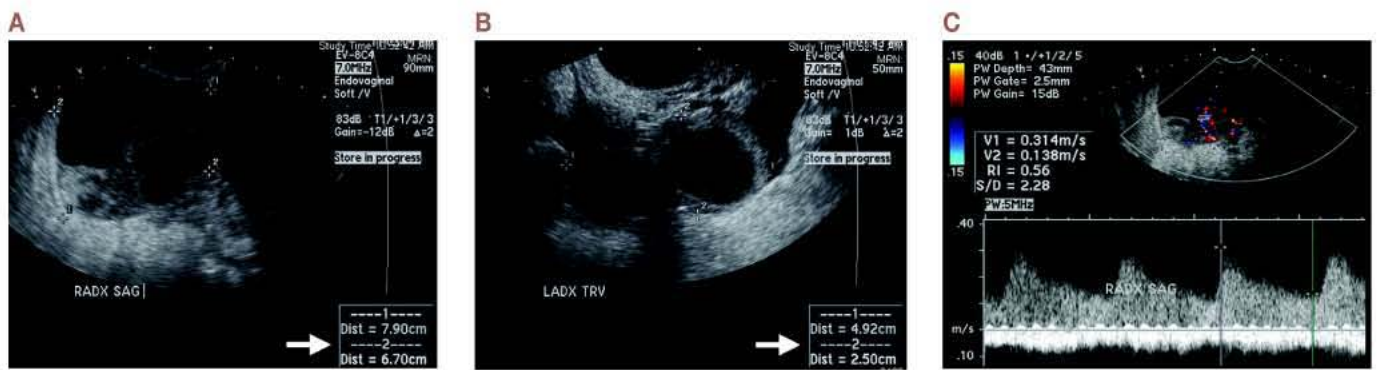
US images show enlarged, multicystic right (A) and left (B) ovaries consistent with OHSS. The right ovary is asymmetrically enlarged (arrow), the only clue to ovarian torsion in this case. (C) Duplex Doppler US image of the right ovary shows arterial and venous flow.
